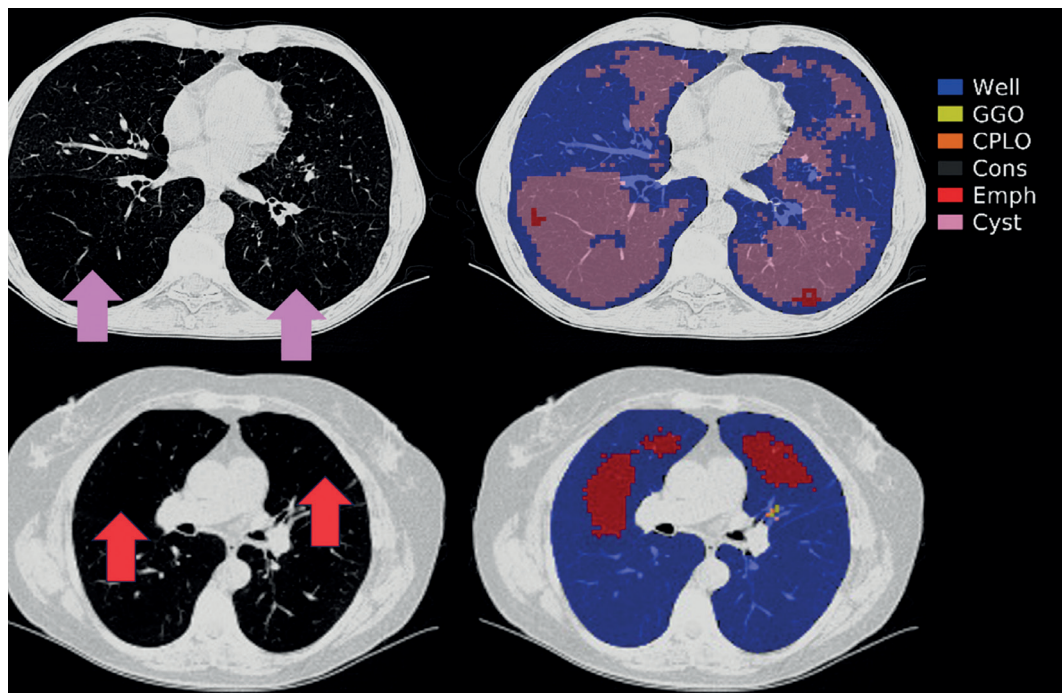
Axial CT scan image obtained in a 54-year-old woman shows multiple low-attenuation areas in a patient with a clinical diagnosis of lymphangioliomyomatosis (LAM) and in a 53-year-old man with pulmonary clinical diagnosis of emphysema (Emph). Pink arrows indicate air space cysts areas, defined appearing as rounded, low-density (dark) areas due to their air content. The walls of these cysts are thin, and usually predominate in the middle and lower lung thirds. Despite these cysts can vary in size they are typically surrounded by normal. Red arrows indicate a moderate centrilobular emphysema defined as many well-defined centrilobular lucencies, occupying more than 5% of any lung zone. In the right side, each respective image colored with each class identified. (Emph, red), normal lung parenchyma (Well, blue), and high attenuation areas, which are typically ground glass opacities (GGO, yellow), crazy paving and linear opacities (CP/LO, orange), and consolidations (Cons, gray)³³.
